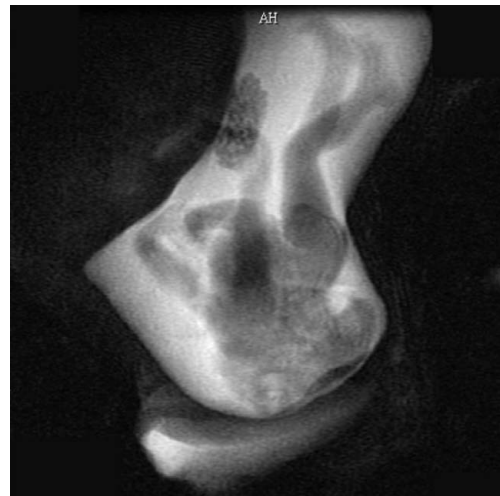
Prenatal magnetic resonance imaging at 17 weeks of gestation shows normal extremities, exencephaly, hyperextension of the fetal head, significant shortening of the spinal column, marked lordosis and hyperextension of the malformed spine, an upward-turned face, and absence of the neck.
